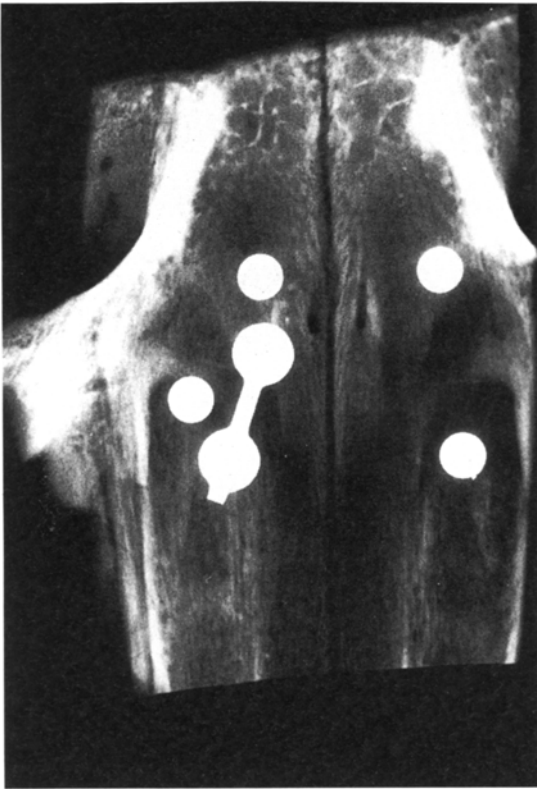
Radiograph showing the microplate and the four reference screws.
